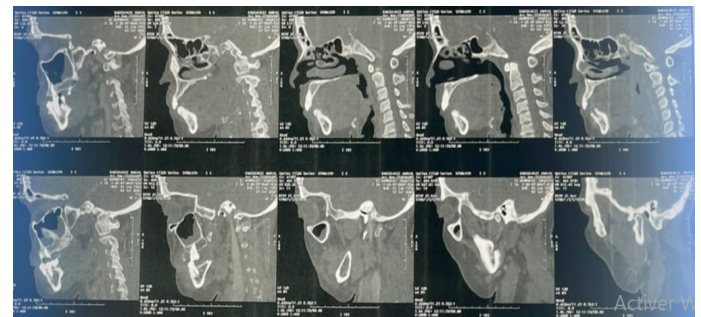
Sagittal CT Reconstruction.
